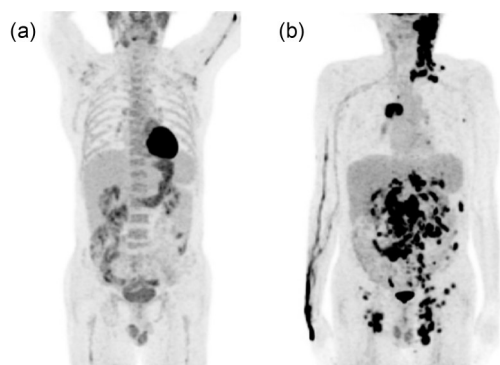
PET/CT scan of Case 2. (a) PET/CT before treatment in December 2017 showed the involvement of bilateral cervical, axillary, hilus of the lung, mediastinal lymph nodes, and subcutaneous lymph nodes of the chest wall, along with increased FDG uptake; (b) PET/CT in June 2021 showed multiple lymph nodes (left retroauricular region, parotid region, neck, supraclavicular region, mediastinal 4R region, left chest wall, bilateral groin, abdominal cavity, and retroperitoneal) along with increased FDG uptake. PET: positron-emission tomography; CT: computed tomography; FDG: fluorodeoxyglucose.
